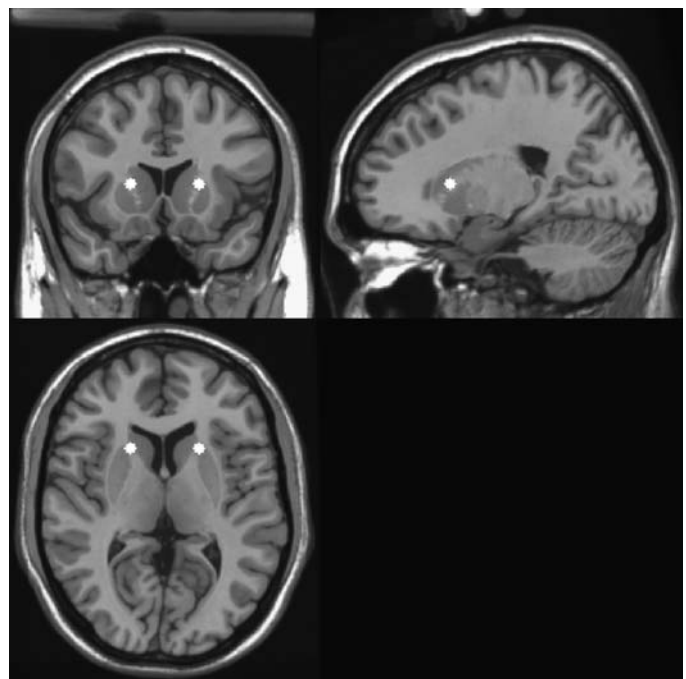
Typical locations of anterior capsulotomy lesions superimposed upon normalized T1 MRI scan. Lesions not to scale.
